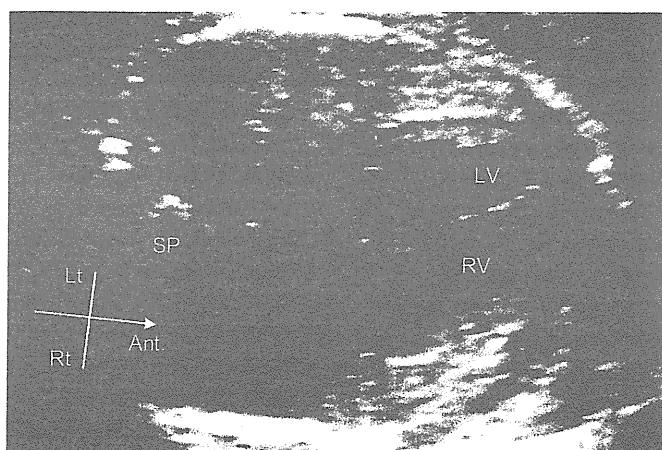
Fetal echocardiographic image of four-chamber view
